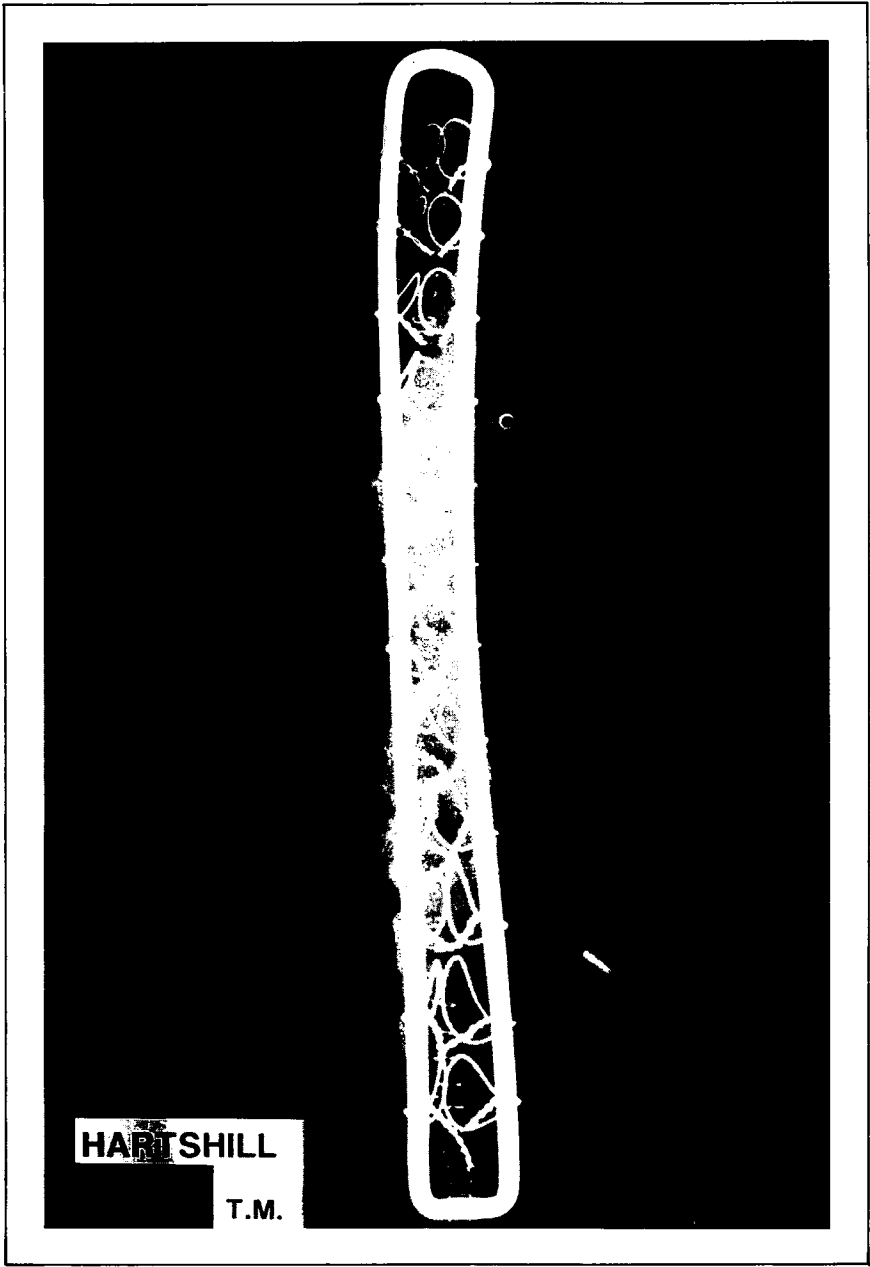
Antero-posterior radiograph of Hartshill rectangle
